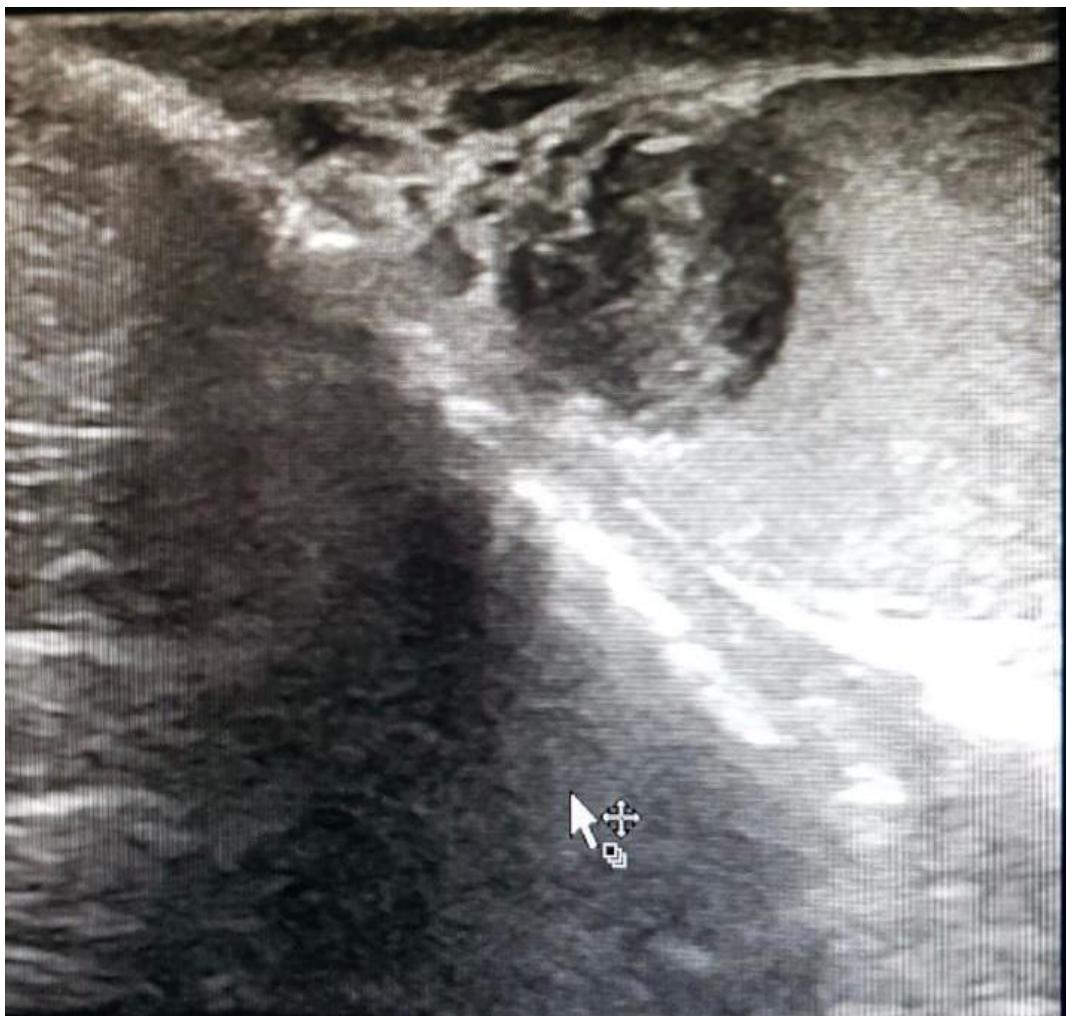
18-year-old male with a testicular epidermoid cyst. Transverse gray-scale sonogram of the right testis identifies a well-demonstrated heterogeneous mass
